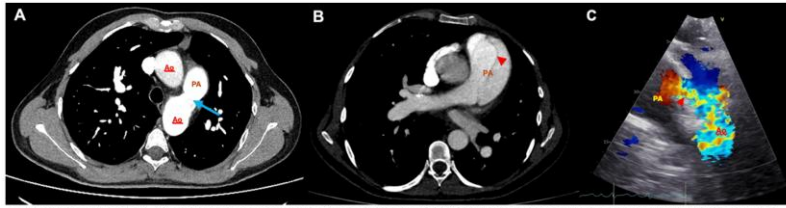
Multimodal imaging. A. CTA showing a large patent ductus arteriosus (blue arrow). B. CTA showing main pulmonary artery aneurysm with intimal dissection flap (red arrowhead). C. Suprasternal color Doppler showing ductal flow between the aorta and pulmonary artery (red arrowhead). Ao: aorta; PA: pulmonary artery.
